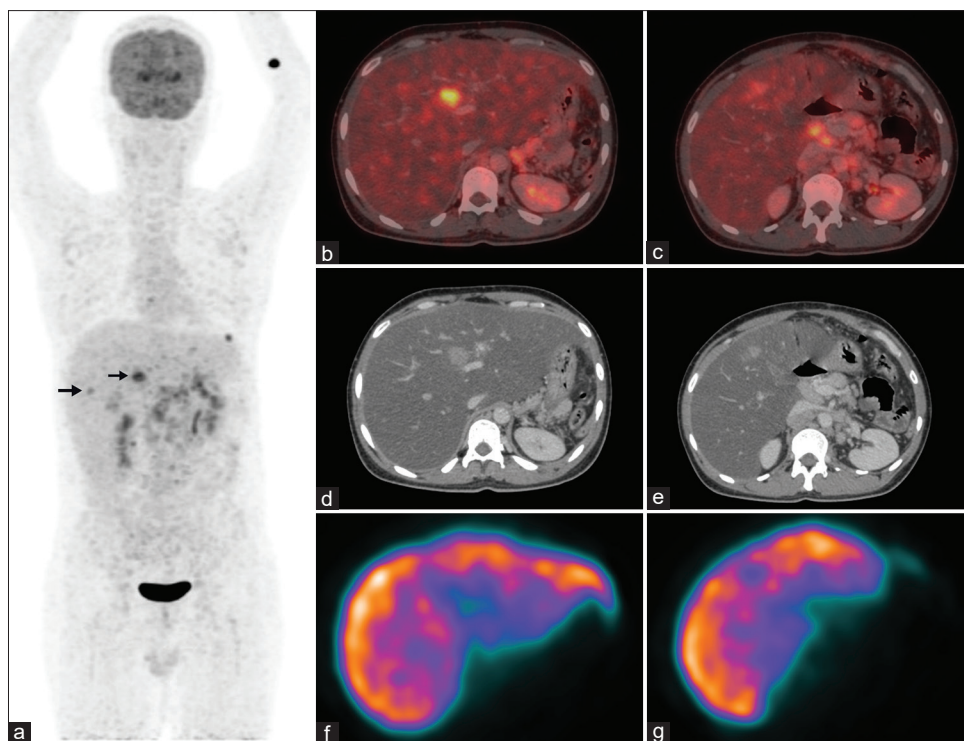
(a) image showing multiple foci of FDG uptake in the abdominal lymph nodes along with multiple foci of increased FDG uptake in the liver (black arrows). Axial fused F-18 FDG PET/CT (b and c) and CECT (d and e) images showing increased focal FDG uptake over hyperdense lesions in Segments IVa and V in the background of diffuse fatty changes. Tc-99m SC SPECT (f and g) images showing areas of photopenia over the corresponding regions in the liver. CT: Computed tomography, FDG: Fluorodeoxyglucose, F-18 FDG PET/CT: F-18 FDG positron emission tomography/CT, SPECT: Single-photon emission CT, SC: Sulfur colloid
